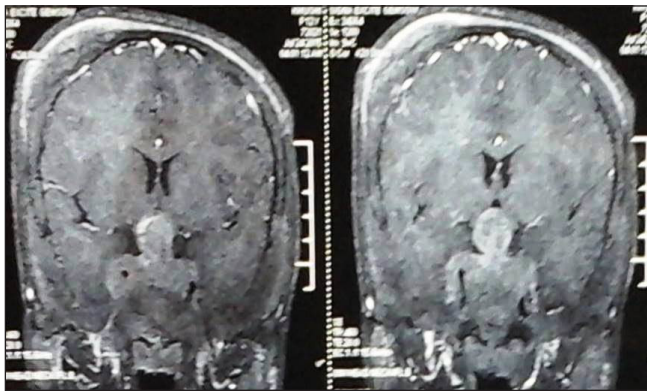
MRI brain coronal T1 weighted postcontrast images reveal heterogeneously contrast enhancing hyperintense sellar and suprasellar mass lesion extending laterally into cavernous sinuses and encasing both internal carotid arteries. Diffuse calvarial thickening and expansion in right high parietal region is also present.
